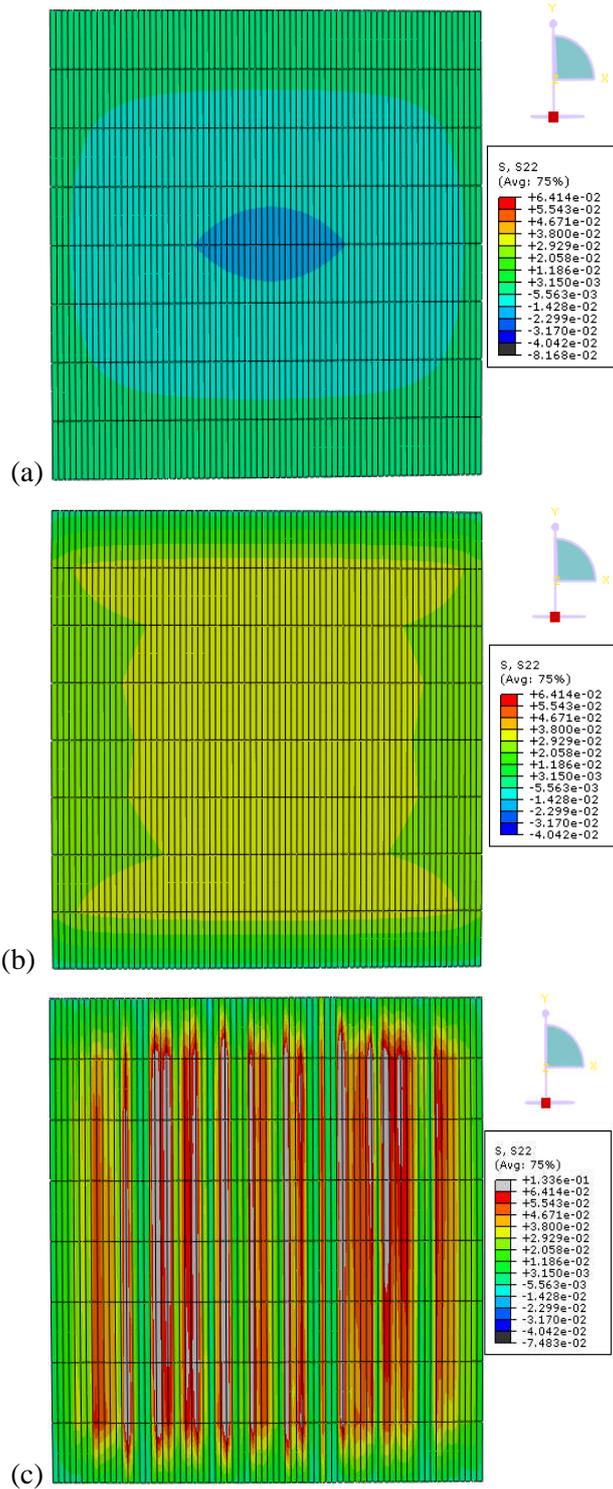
Stress along global Y-axis (S_{22} ; MPa) on cartilage surface of (a) the Isotropic-3D, (b) the Uniform-3D and (c) the DT-MRI-3D model at the end of ramp loading ($t = 2s$).
